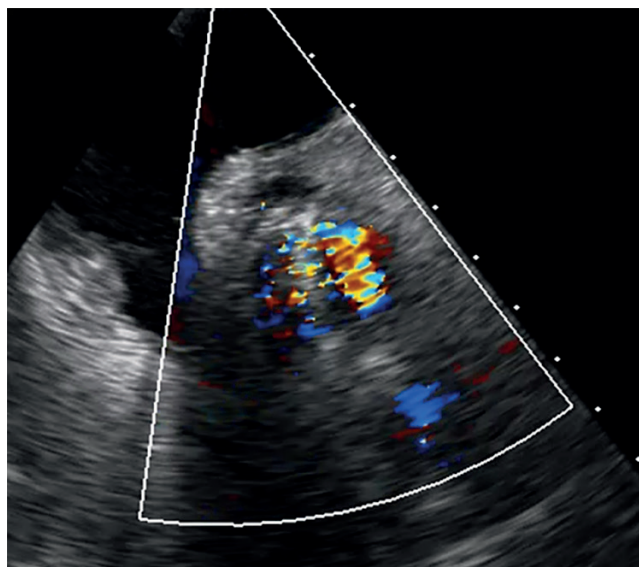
Echocardiographic image of the replaced mechanical aortic valve.
